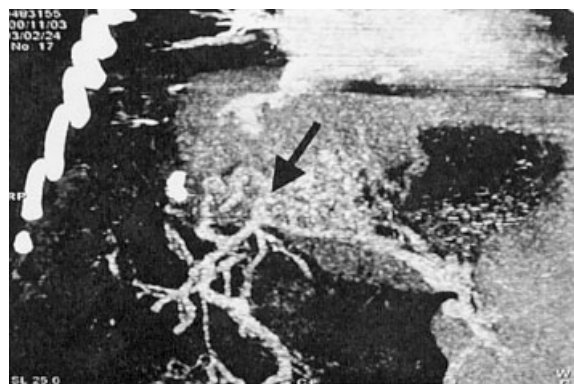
CT angiography shows complete occlusion of the portal vein (black arrow; \dagger) with cavernous transformation at the hepatic hilar region.
